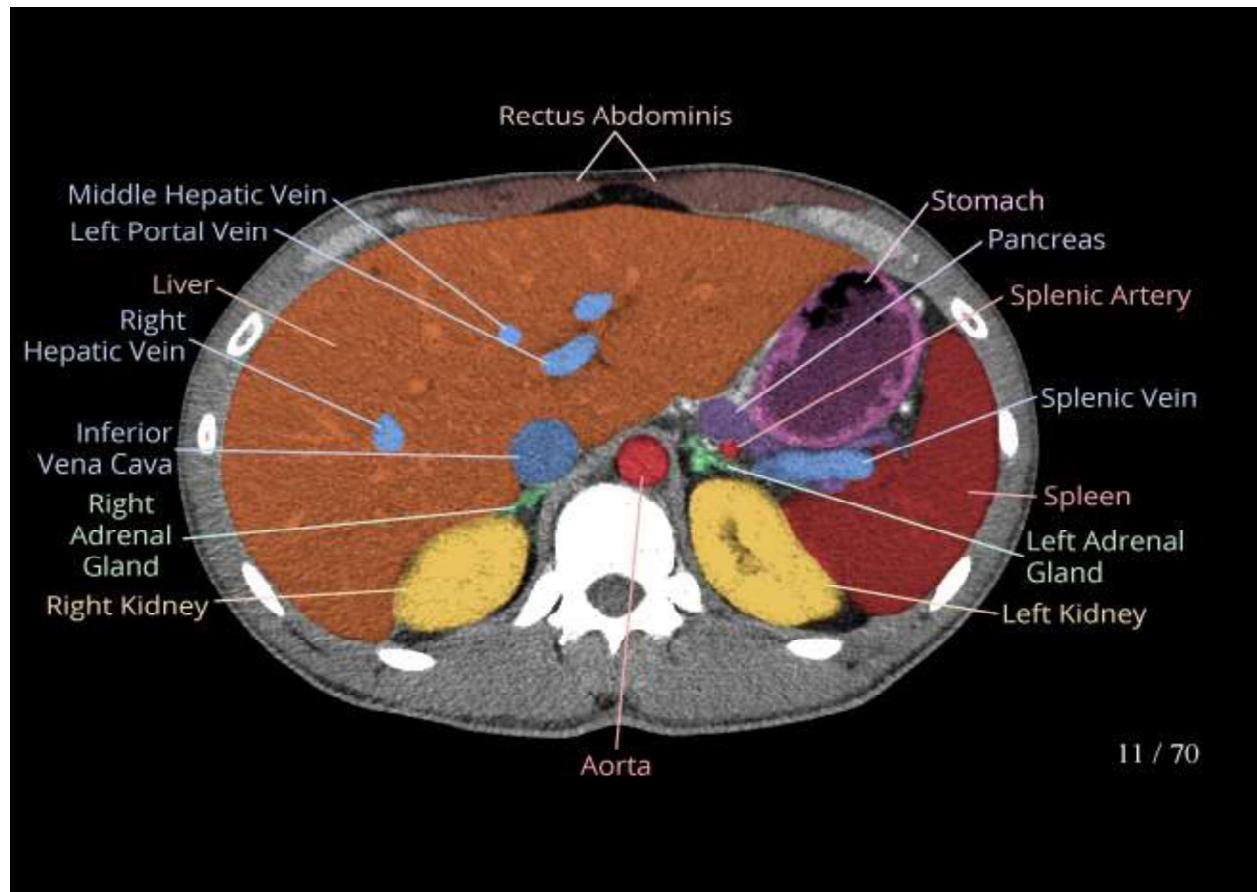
CT images of abdomen
